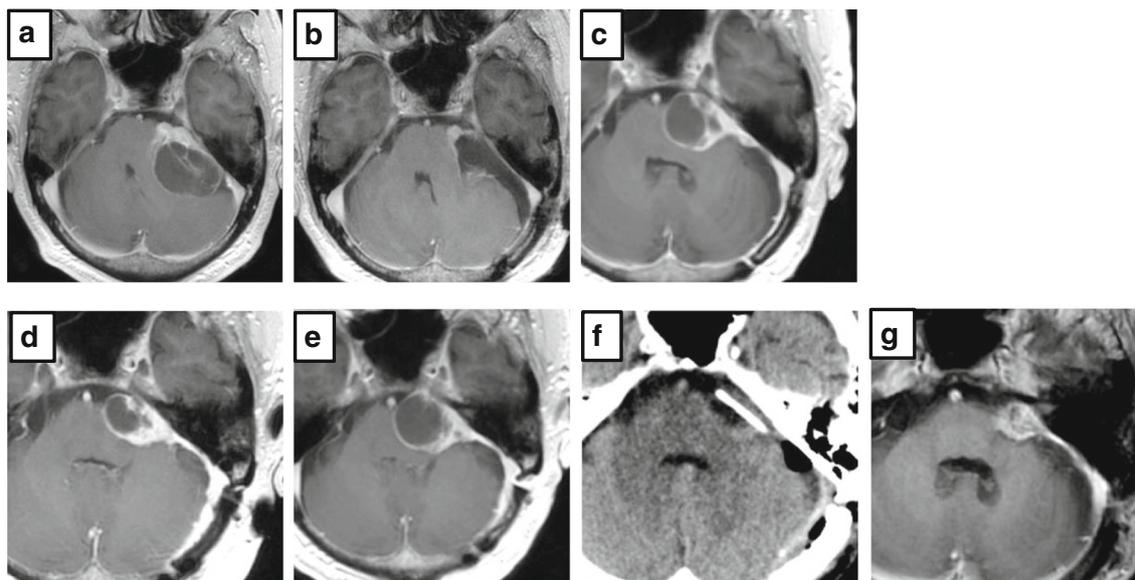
The clinical course in this case. a Preoperative axial T1-weighted MR image after gadolinium contrast demonstrating a large cyst in the left cerebellopontine angle (maximum cyst diameter 50 mm). b Postoperative T1-weighted MR image after gadolinium contrast demonstrating subtotal resection and residual tumor capsule. c Axial T1-weighted MR image after gadolinium contrast prior to the second surgery demonstrating cyst regrowth. d, e Axial T1-weighted MR image after gadolinium contrast
